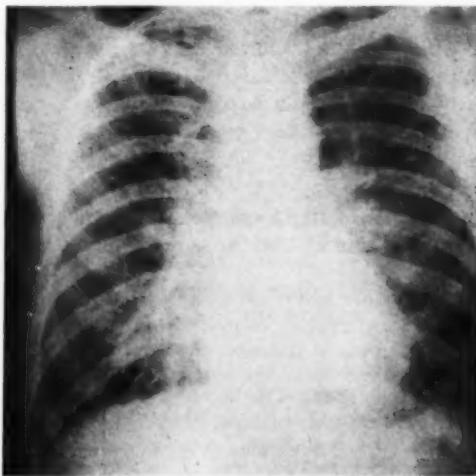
Increased density and extent of hilar vascular markings, with linear and small stippled areas of increased density fanning outward from the hilus. The heart shadow is slightly enlarged. The changes are those of pulmonary congestion. The patient died three days later, autopsy demonstrating focal areas in which the alveoli were packed with red blood corpuscles, with focal areas of atelectasis and edema. Roentgenograms were not taken just prior to death.
